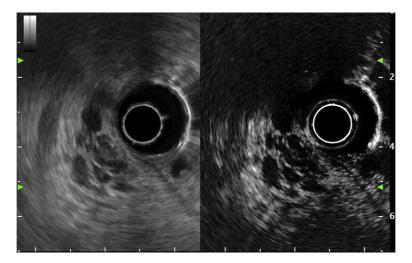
Endoscopic ultrasonographic findings. Left: B mode, Right: contrast mode. Findings of wall thickening in the IPMN were noted, but there were no nodules on contrast EUS mode. IPMN: intraductal papillary mucinous neoplasm, EUS: endoscopic ultrasonography
